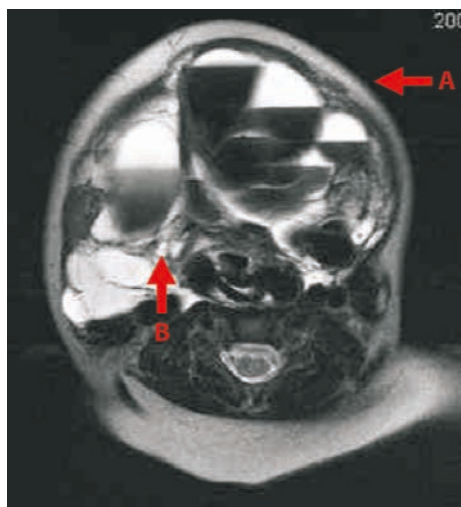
MRI lymphatic malformation demonstrating both micro- (vertical arrow) and macrocysts (horizontal arrow) as well as fluid/fluid levels
